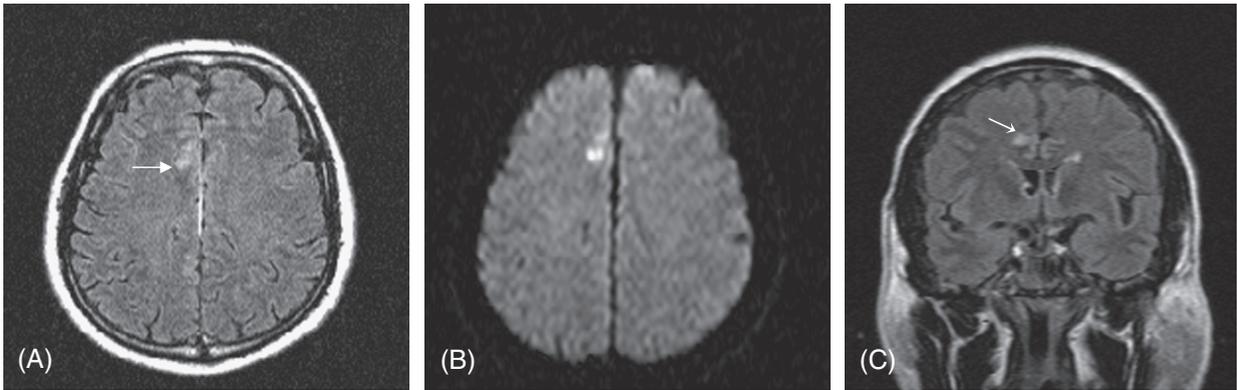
MRI scan of a hypertensive 57-year-old man presenting with left leg weakness, showing a small infarct in the territory of the right anterior cerebral artery on FLAIR (A axial, C coronal) and diffusion weighted sequences (B).
